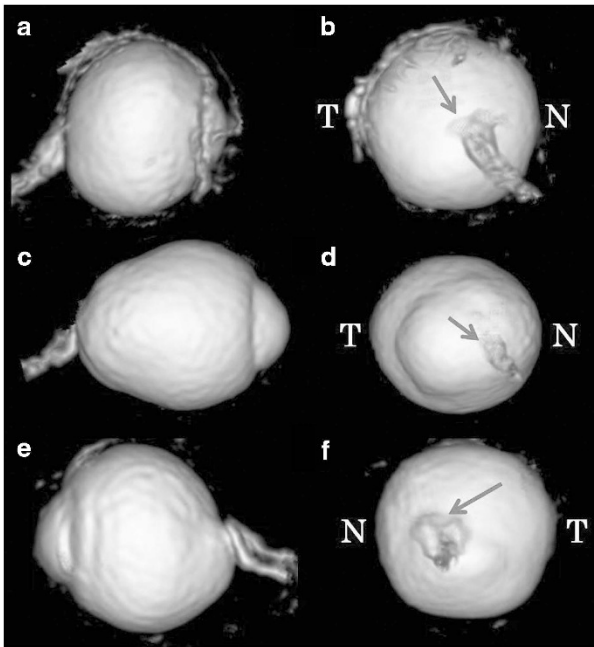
Spatial relationship between the attachment site of the optic nerve and the entire eye based on 3D MR images of eyes with and without TDS. (a, b) Nasal view (a) and posterior view (b) of an emmetropic eye. The axial length of the eye is 23.8 mm. The shape of the posterior segment of the eyes is symmetrically hemispheric. The attachment site of the optic nerve is slightly nasal from the center of the posterior segment (b, arrow), and the optic nerve is attached perpendicularly to the globe (a). The curvature of the attachment site of the optic nerve is vertically straight when the globe is viewed from the nasal side (a). (c, d) Nasal (c) and posterior (d) views of a highly myopic eye without TDS. Axial length of the eye is 29.9 mm. The eye is elongated in anterior–posterior direction and a posterior protrusion exists along with the visual axis (c). The attachment site of the optic nerve is in the middle of the protrusion (c, d arrow), and the optic nerve is attached perpendicularly to the globe (c). The curvature of the attachment site of the optic nerve is vertically straight when the globe is viewed from the nasal side (c). The lower boundary of the posterior protrusion can be clearly seen (d). (e, f) Nasal (e) and posterior (f) views of an emmetropic eye with TDS. Axial length of the eye is 23.7 mm. The lower half of the globe has a completely different curvature from the upper half of the eye (e). The expansion of lower globe is wide and the lower boundary of the inferior staphyloma is not obvious (f). The optic nerve is attached along the upper edge of posterior protrusion and the curvature of the attachment site of the optic nerve is oblique when the globe is viewed from the nasal side (e, f arrow). N, nasal; T, temporal.
